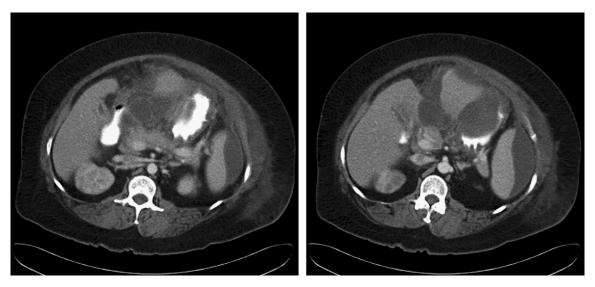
Representative images from computed tomography of a patient with large peripancreatic fluid collection secondary to gallstone pancreatitis. Fluid is seen occupying the lesser sac and surrounding the spleen. Laparoscopic cholecystectomy was performed safely 56 days after endoscopic sphincterotomy.
